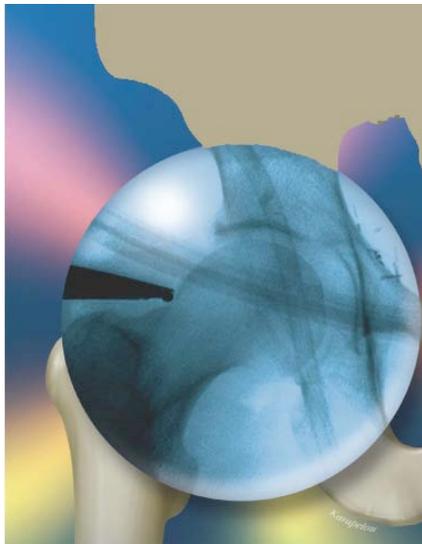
Xray guidance for entry into the joint.
